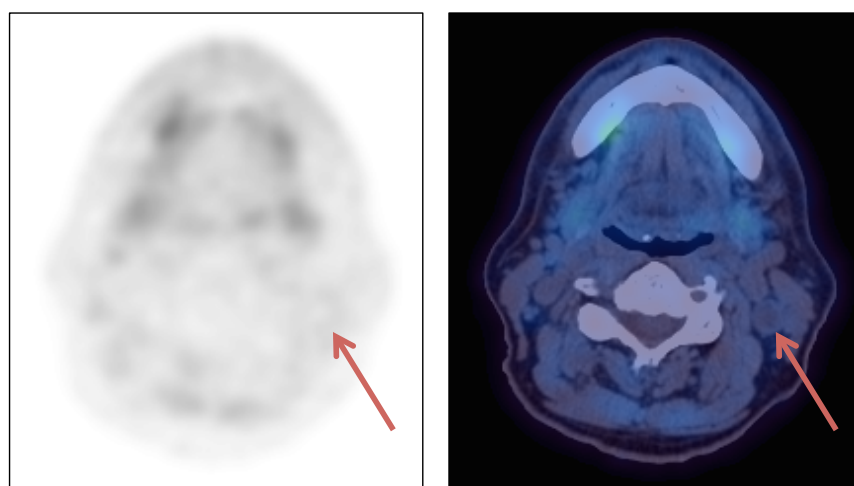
Lymph node visible on CT (right) but not on ⁶⁴Cu-ATSM PET (left).
